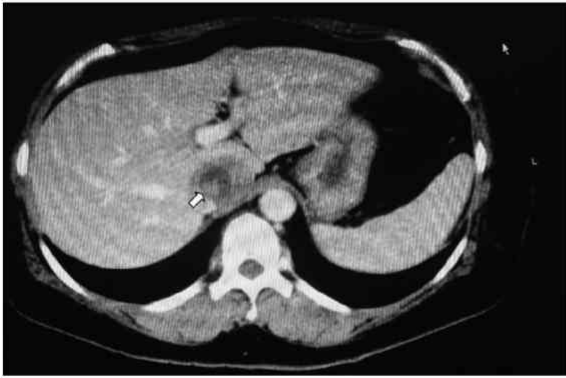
Contrast-enhanced CT images acquired during the warfarin-free period. Recurrent thrombus along the mass in the IVC is shown.
